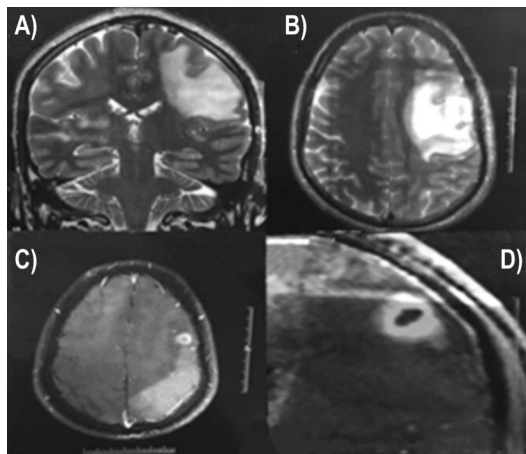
The MRI of brain with contrast in Fortis Hospital Limited in Mumbai, India on 02 December 2019. A) In frontal section persistent small well-defined heterogeneously enhancing conglomerate lesion involving left frontal lobe with surrounding mild perilesional oedema with minimal blooming in gradient is revealed. B) C) D) In cranio-caudal dimension at different degrees of depth the conglomerate lesion measured 9x10 mm in axial dimensions and 15.5mm in cranio-caudal dimension is depicted
